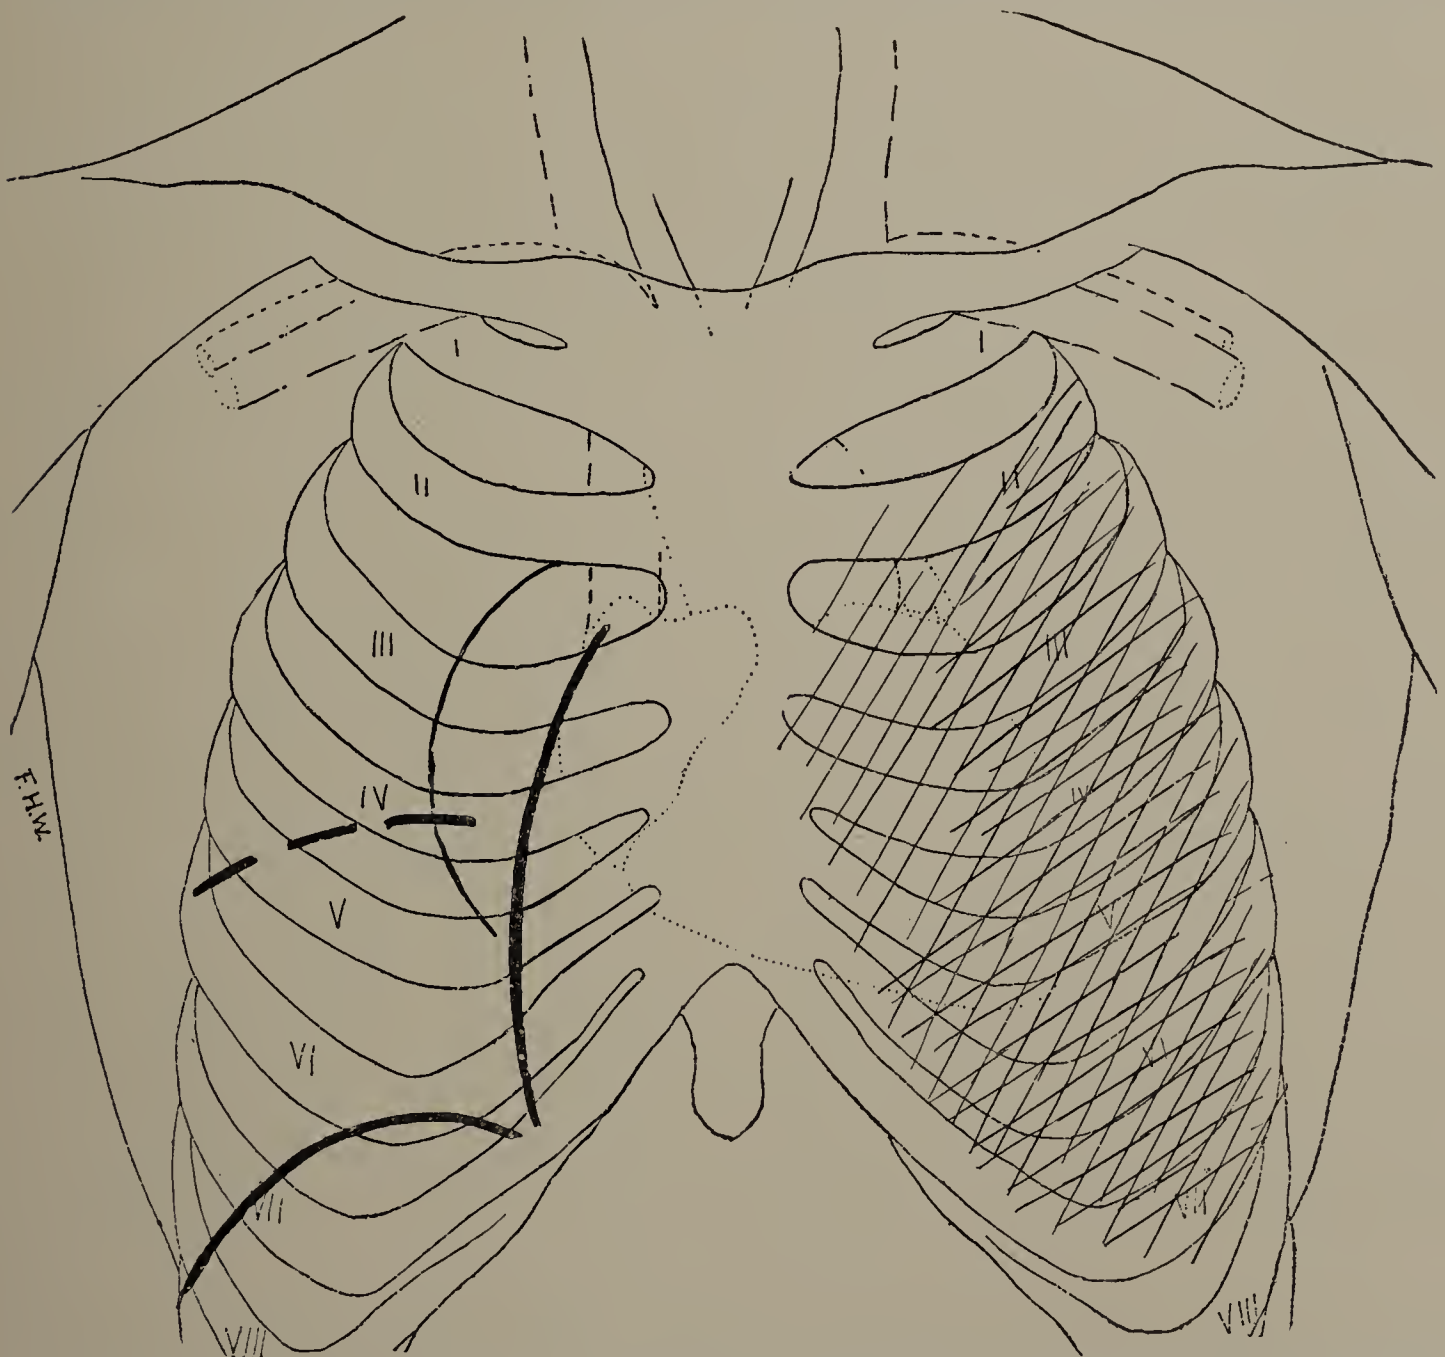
Thomas R. April 26. Third X-ray examination with screen. Right side perfectly clear; first, second, and third ribs seen on left side; no outline of left border of heart visible; heart still displaced to right. (Cut one-third life size.)
